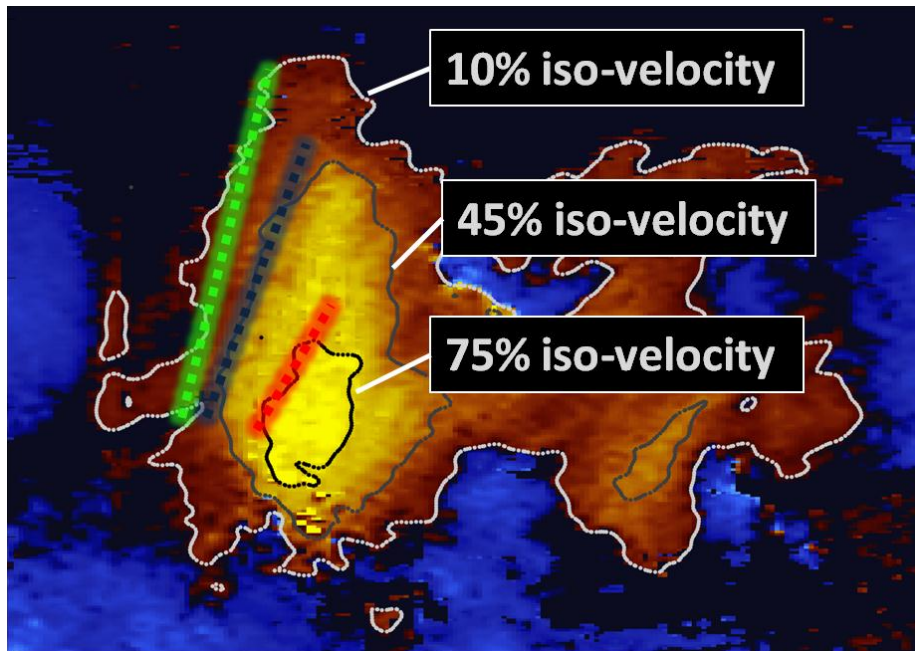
An example CMM echocardiogram showing the dependence of conventional propagation velocity on the choice of iso-velocity contour. The green line follows the motion of the 10% iso-velocity contour and is moving much more rapidly than the red line which is following the motion of the 75% iso-velocity contour. This motivates moving away from iso-velocity assumptions and tracking the true wave.
